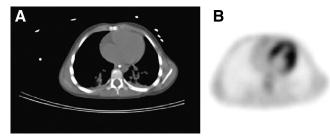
PET/CT scan of 3-y-old boy with recurrent neuroblastoma. (A) Chest CT scan shows bibasilar atelectasis. (B) Corresponding PET image shows no abnormal ¹⁸F-FDG accumulation in areas of atelectatic lungs.
